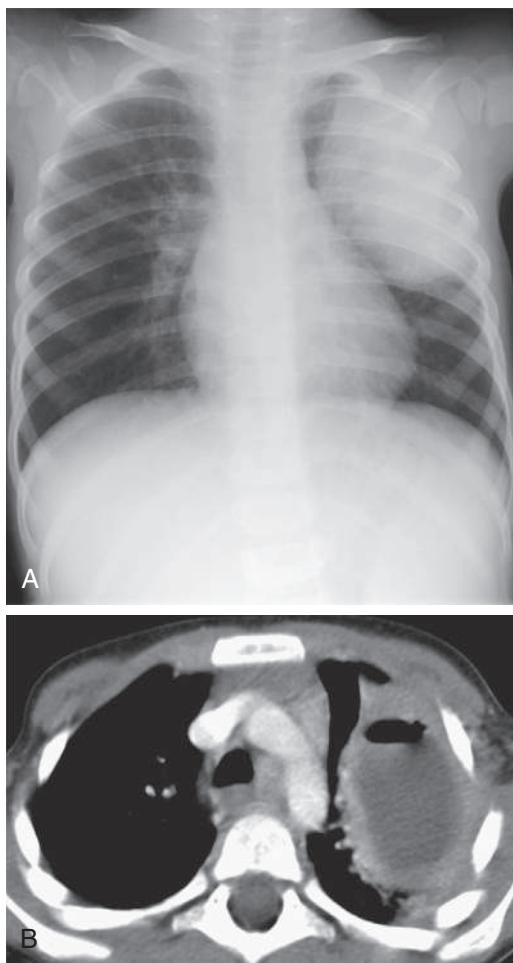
Pulmonary abscess in a 2-yr-old male with persistent cough. A, Chest radiograph shows large oval mass in the left upper lobe. B, CT scan demonstrates an abscess with a thick enhancing wall that contains both air and fluid. (From Slovis T, ed. *Caffey's Pediatric Diagnostic Imaging*, 11th ed. Philadelphia: Mosby; 2008, Fig. 78-3, p. 1297.)
